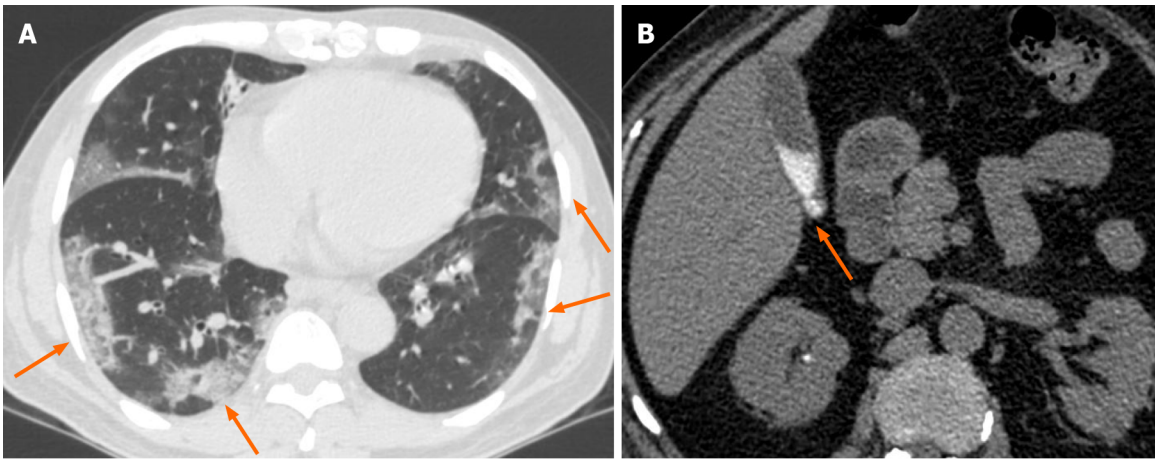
Evidence of cholestasis in a critically ill coronavirus disease 2019 patient. A: Axial chest computed tomography (CT) image shows multiple peripheral ground glass opacities associated with interstitial thickening in both lung fields (orange arrows in A); B: Axial non-contrast CT image of the abdomen shows incidentally detected hyperdense sludge within the gall bladder lumen (orange arrow in B), suggesting cholestasis.
